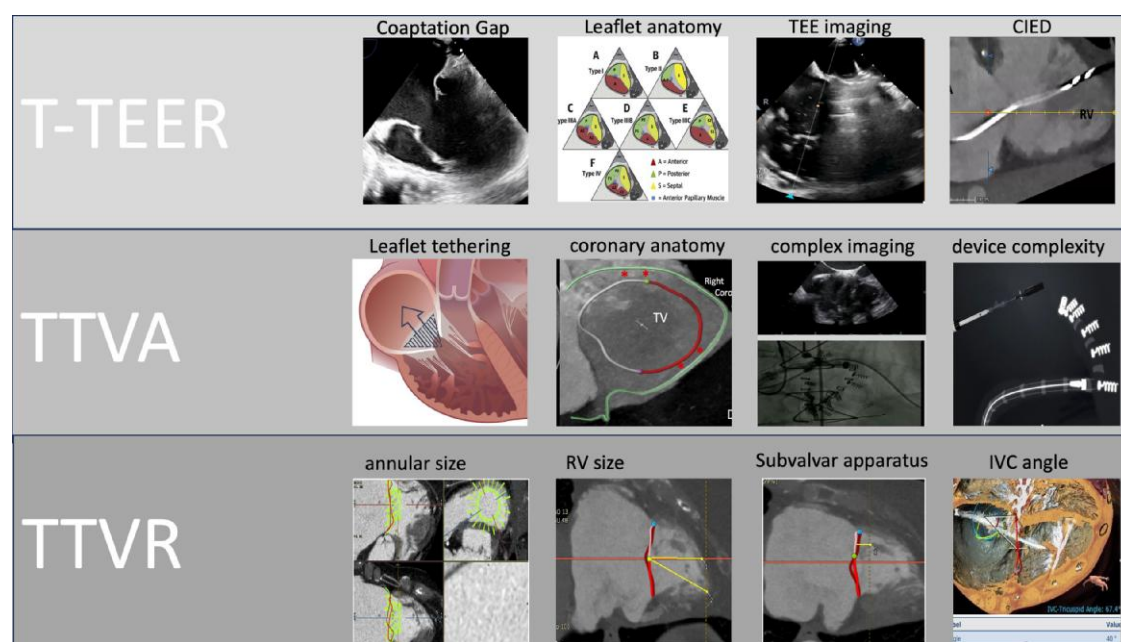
Device selection: key constraints of various tricuspid regurgitation treatment technologies. This figure outlines the technical obstacles for each tricuspid regurgitation treatment technology. Tricuspid transcatheter edge-to-edge repair effectiveness is constrained by factors such as the coaptation gap, leaflet number and distribution, transoesophageal echocardiography image quality, and the presence of transvalvular leads. Transcatheter tricuspid valve annuloplasty applicability is limited by the extent of right ventricular remodelling, leaflet tethering, proximity of the right coronary artery to the annulus, as well as device complexity and imaging requirements during the procedure. Transcatheter tricuspid valve replacement faces limitations due to the annulus size and shape, right ventricular dimensions, subvalvular apparatus anatomy, and the venous system's size and anatomy, with specific devices presenting unique anatomical contraindications (T-TEER, tricuspid transcatheter edge-to-edge repair; TTVA, transcatheter tricuspid valve annuloplasty; TTVR, transcatheter tricuspid valve replacement)
